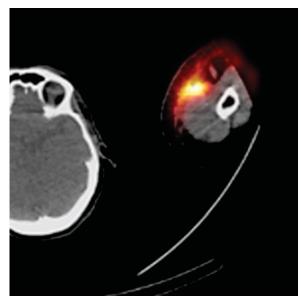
An extravasation of [177Lu]Lu-DOTATOC as imaged by SPECT/CT showing diffuse transition from areas of high activity to low.
